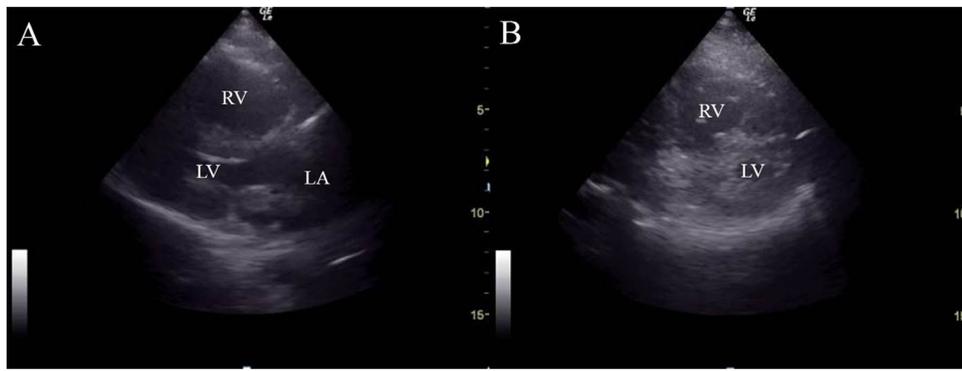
Transthoracic echocardiography. (A) Parasternal view, showing a marked dilation of the right ventricle (RV) and compression of the left ventricle (LV); the left atrium (LA) is also observed. (B) On the short-axis view, a D-shaped septum is observed.
